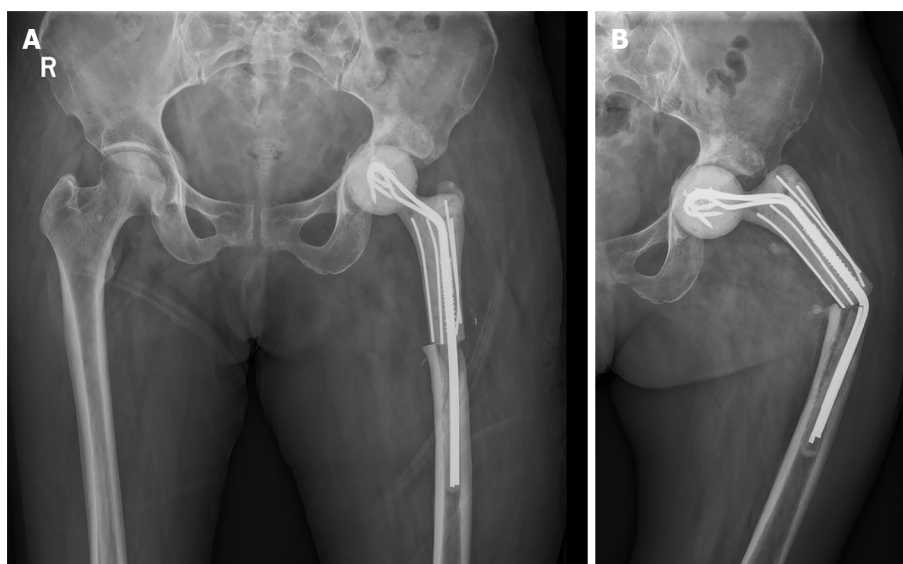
Radiographs of the pelvis taken the day after the first-stage revision (anteroposterior plane) (A) and the left hip taken 6 mo after the first-stage revision (B). The spacer stem was bent (anteroposterior plane).
